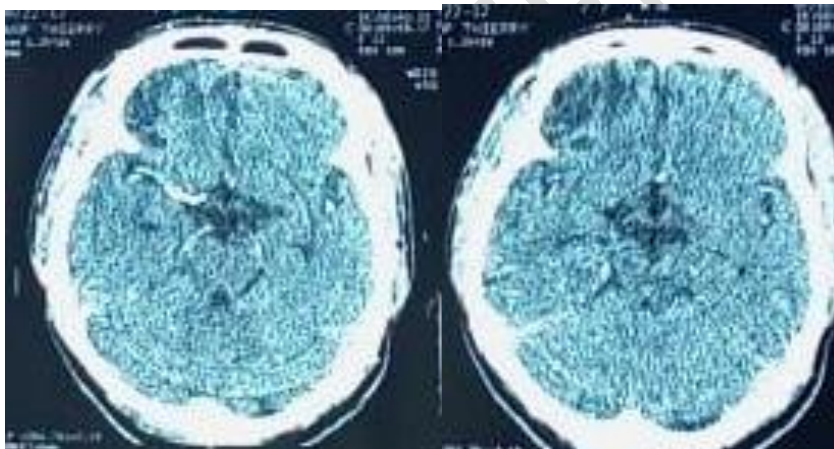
J 40 CT Inject and my inject, showing right frontal hypodensity
